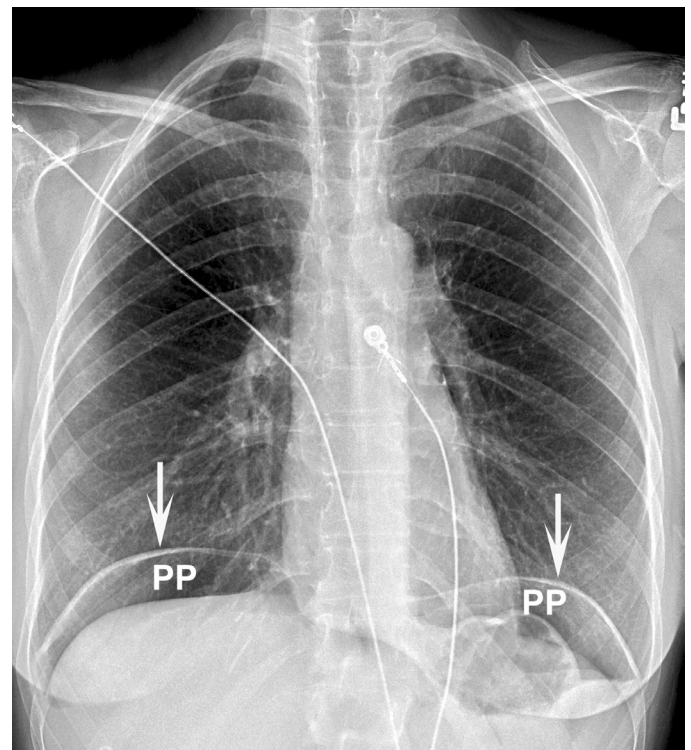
■ Posteroanterior (PA) upright chest x-ray. Lucencies below and, importantly, outlining the hemidiaphragms (*white arrows*) indicate a pneumoperitoneum (PP).
